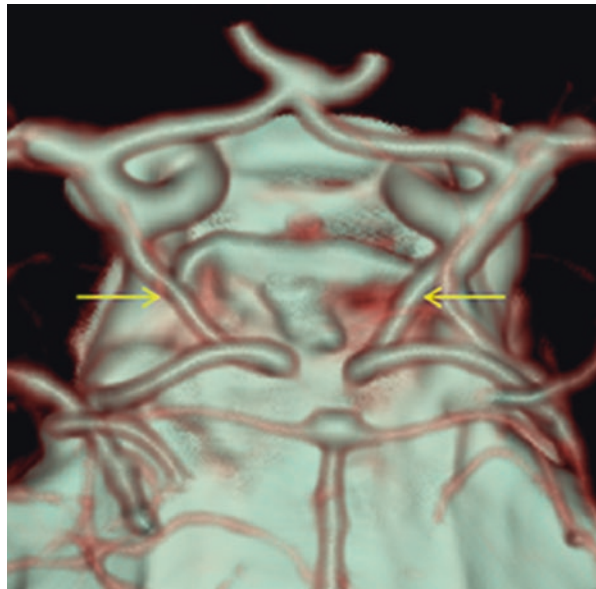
CTA (VRT 3D reconstructions) shows bilateral Fetal Pcom (yellow arrows) (Reproduced from Zampakis et al. [6])
